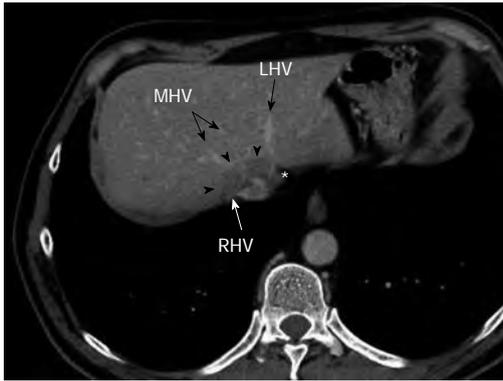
Preoperative multidetector computed tomograph at portal venous phase showing a large metastasis (arrowheads) encircling the confluence of the right hepatic vein and middle hepatic vein, without any thrombosis, and displacing the end of the left hepatic vein (asterisk). RHV: Right hepatic vein; MHV: Middle hepatic vein; LHV: Left hepatic vein.
